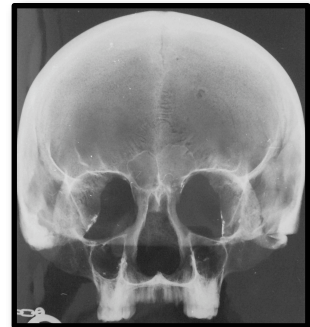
X-ray of the skull of Mozart showing the frontal sinus, which is the most likely cause of the metopic protruberance
